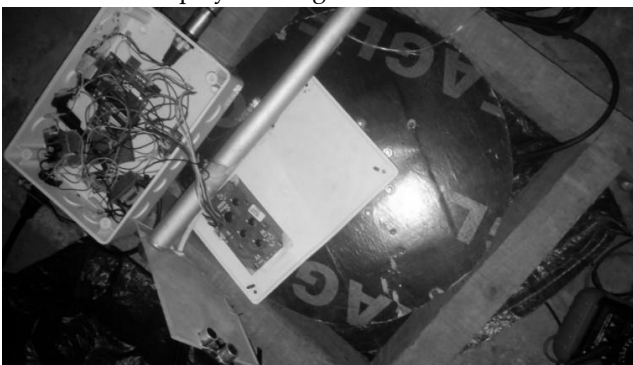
The snap shot of the developed BMI machine showing the internal circuitry and the ultrasonic sensor
